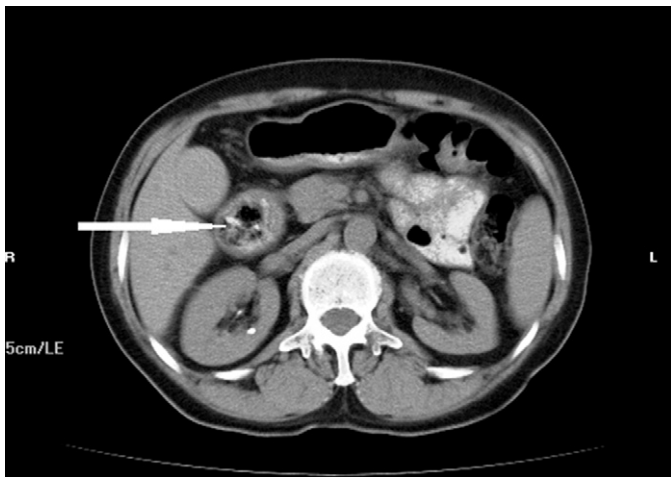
Contrast-enhanced abdominal CT scan shows a well-defined mass with mottled appearance within diverticulum on the lateral wall of the second portion of the duodenum (arrow).
